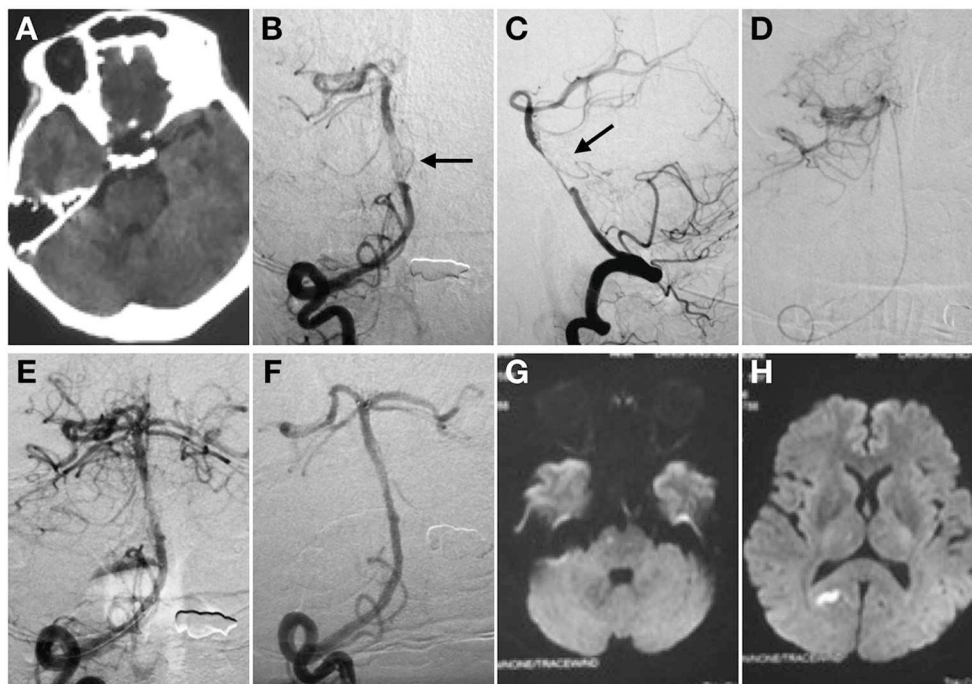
Spontaneous basilar artery (BA) dissection causing acute ischemic stroke. Non-contrast CT (A). Anterior (B), and lateral (C) projection of angiography before stent deployment. There is a “non-occlusive thrombus” in the mid-BA with regular residual lumen (C). Intracranial atherosclerotic stenosis was then suspected (black arrow). The super-selective angiography control was performed to confirm the tip of the microcatheter in the real lumen (D). Angiography after the first mechanical thrombectomy maneuver (E). No clot was found. Angiography immediately after stent detachment showed the stent restored the BA caliber (F). The distal marker of the stent lined up with the BA tip whereas the proximal marker was located within the right vertebral artery. MRI in transverse DWI section showed acute infarctions in right pons (G) and occipital lobe (H) after procedure.
